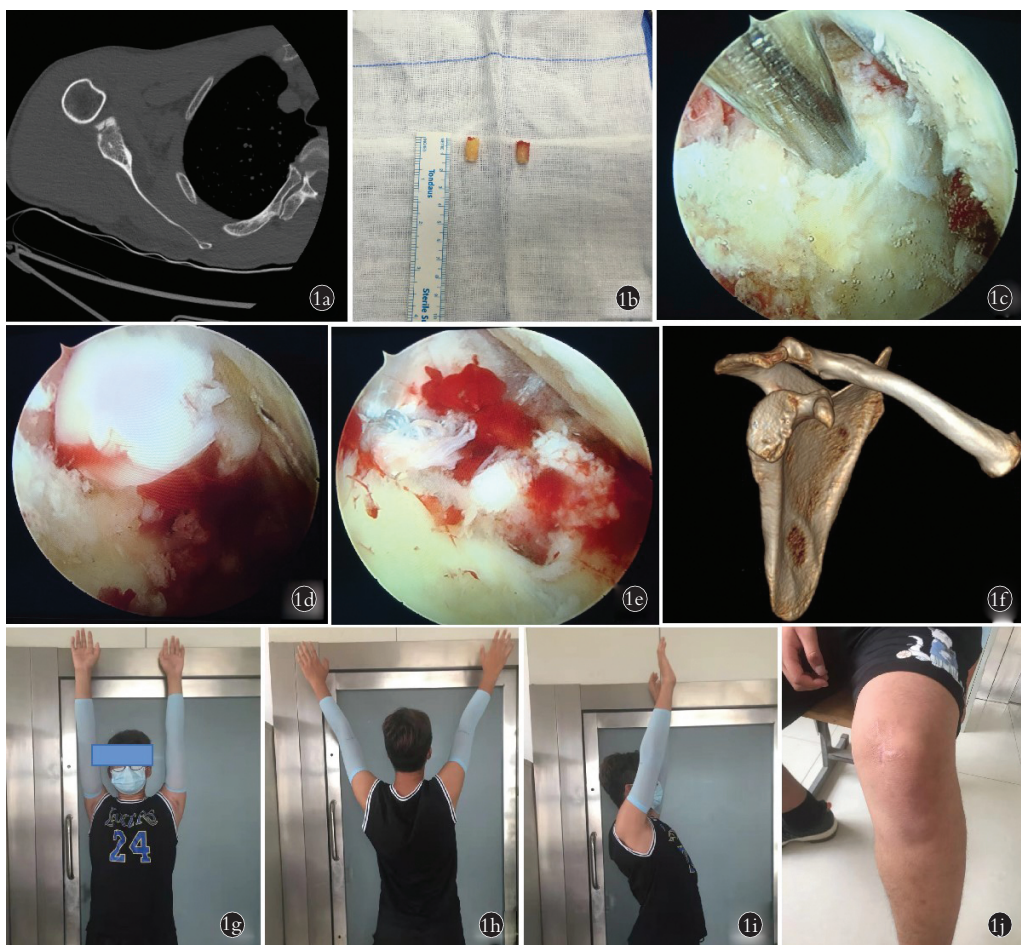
患者,男,17岁,复发性肩关节前脱位 1a.术前 CT 骨窗提示肩关节孟前下撕脱性骨折伴骨质缺损 1b.用自体骨软骨取材器(osteochondral autograft transfersystem,OATS)制备膝关节非负重区骨软骨柱(6 mm×15 mm) 1c.镜下 5 点钟位置制备骨隧道 1d.镜下将骨软骨柱植入骨隧道 1e.镜下孟唇缝合 1f.术后 1 年肩关节盂 3D-CT 1g,1h,1i.患者恢复后 1 年术侧肩关节活动度良好,与健侧活动度无明显差异 1j.术后 1 年左侧软骨柱供区膝关节活动度良好,无疼痛等不适
